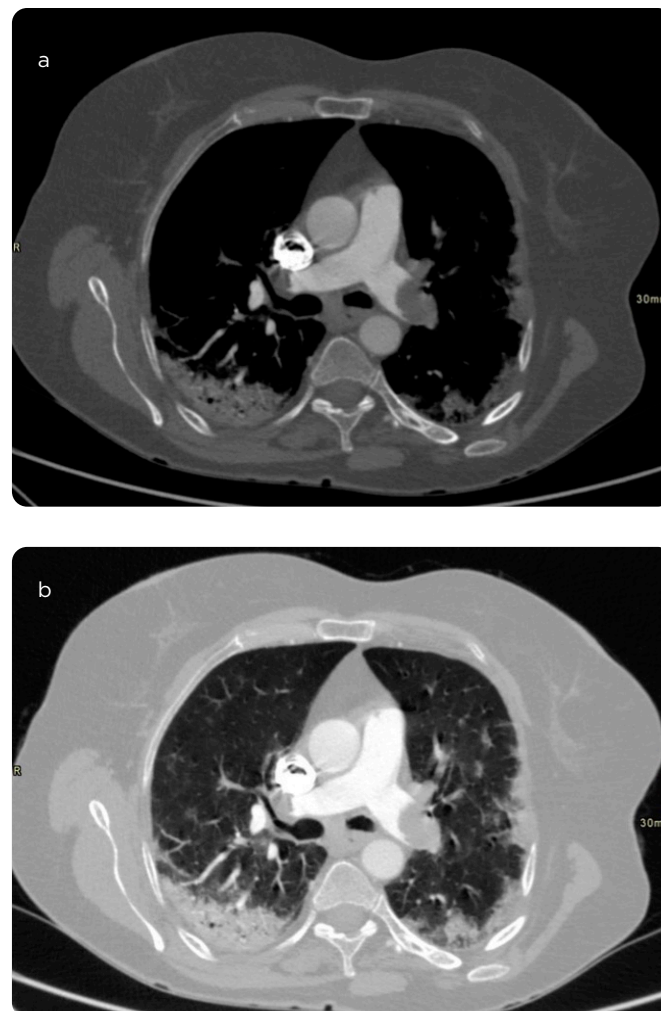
Chest CT angiography of a 59-year-old patient, a) lung window and b) mediastinal window. Positive findings for PE with bilateral involvement of main pulmonary arteries associated with bilateral subpleural consolidations predominantly in the lower lobes, in relation to COVID-19 viral pneumonia (typical pattern).
